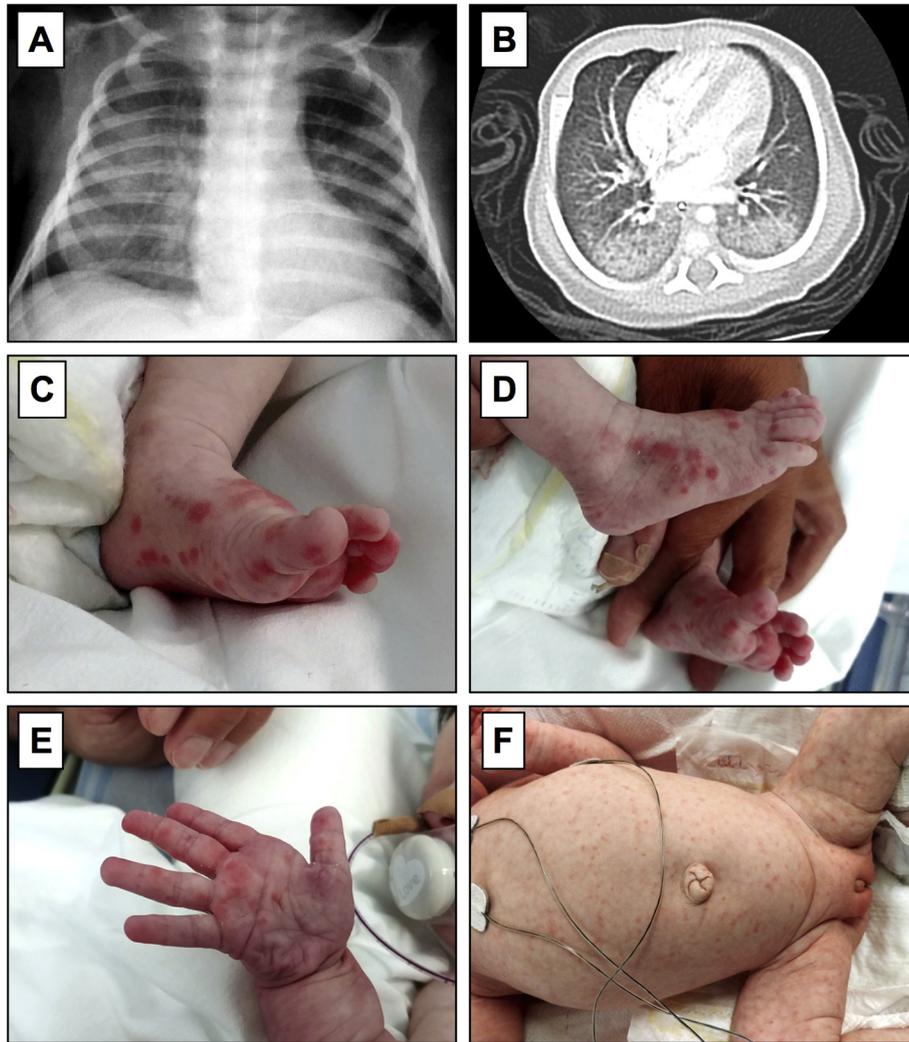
Chest X-ray (A) and CT scan (B) images of interstitial lung disease. Maculopapular skin rash on extremities (C,D,E) and a different one on the whole body (F).
